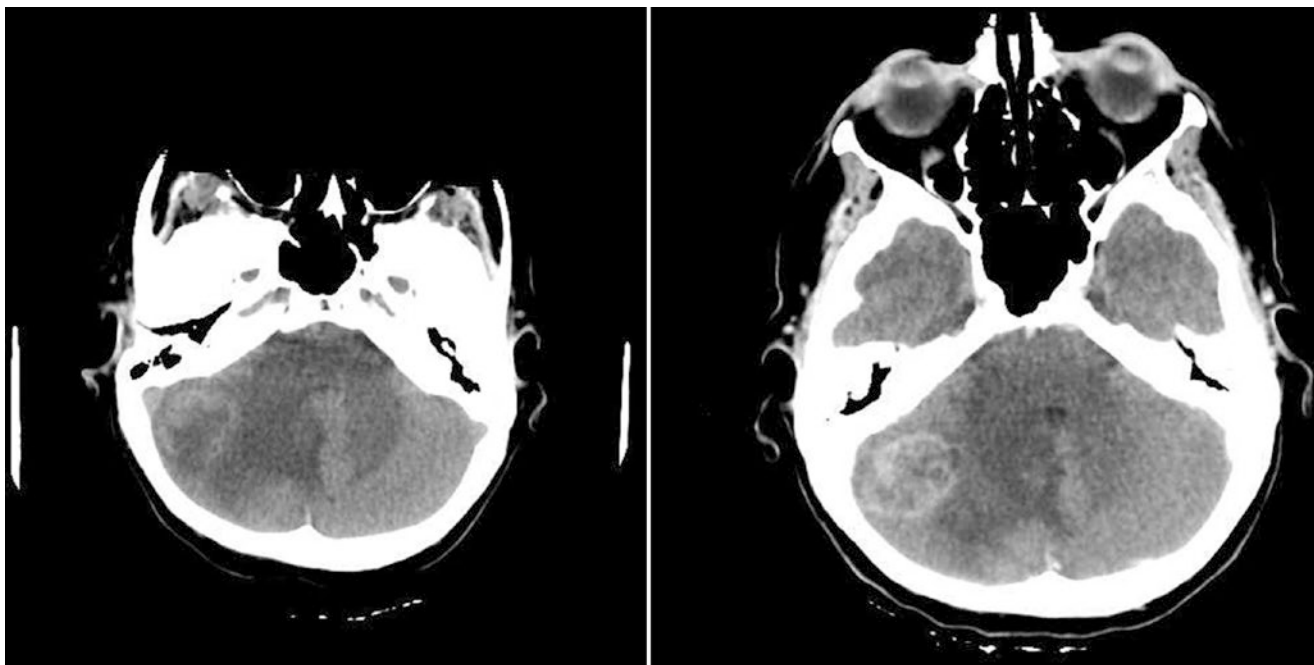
Secondaries. Axial CT scan (right) without contrast. The left image with contrast shows multiple enhancing hyperdense areas. (Reproduced with permission from Dr. Andrew-Owen Jones)
